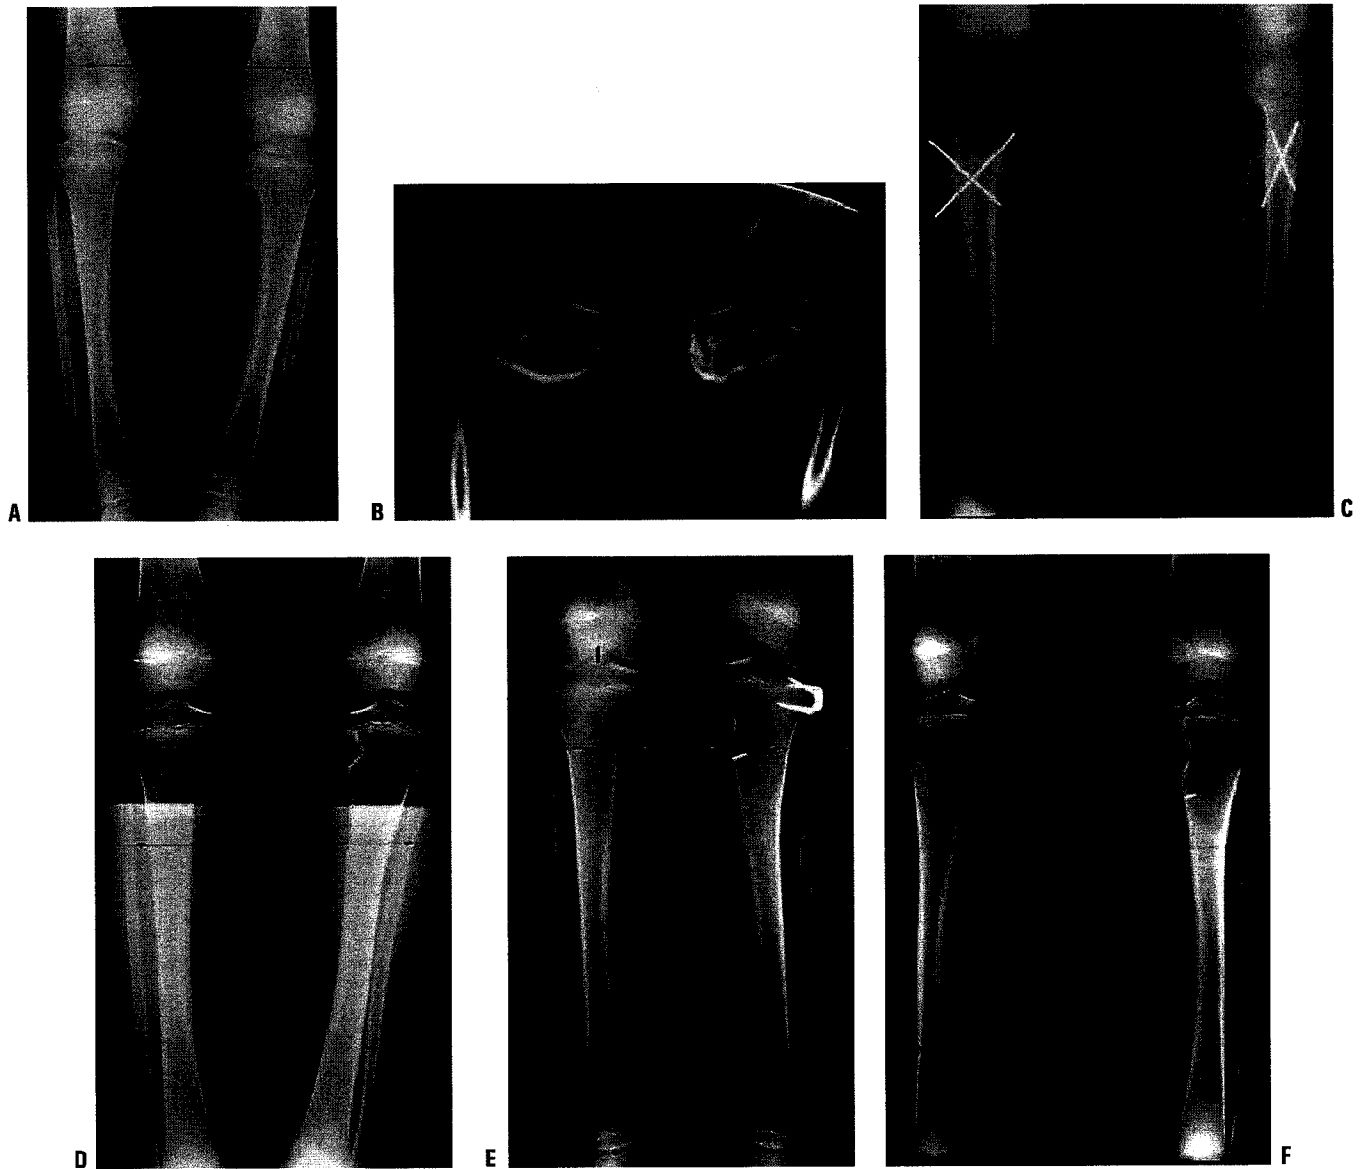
A: These AP radiographs show focal changes of unilateral stage IV Blount disease. The medial tibial physis is indistinct. These changes are suggestive of physeal bar formation. B: A CT scan shows the deformity in the medial physis. The growth plate has a vertical rather than horizontal orientation. A bridge of bone is clearly evident here. Varus will rapidly recur following osteotomy if the physeal bar is not recognized and treated. C: These postoperative films show correction of the varus and resection of the bar. The defect created by excision is filled with radiolucent methylmethacrylate (Cranioplast). D: Subsequent films show recurrent bar formation with gradual loss of correction over 2 years. E: A second excision of the physeal bar along with lateral physeal stapling has resulted in improved alignment. F: Following removal of the staples, varus has gradually recurred. The abnormal medial physis tends to close prematurely.
